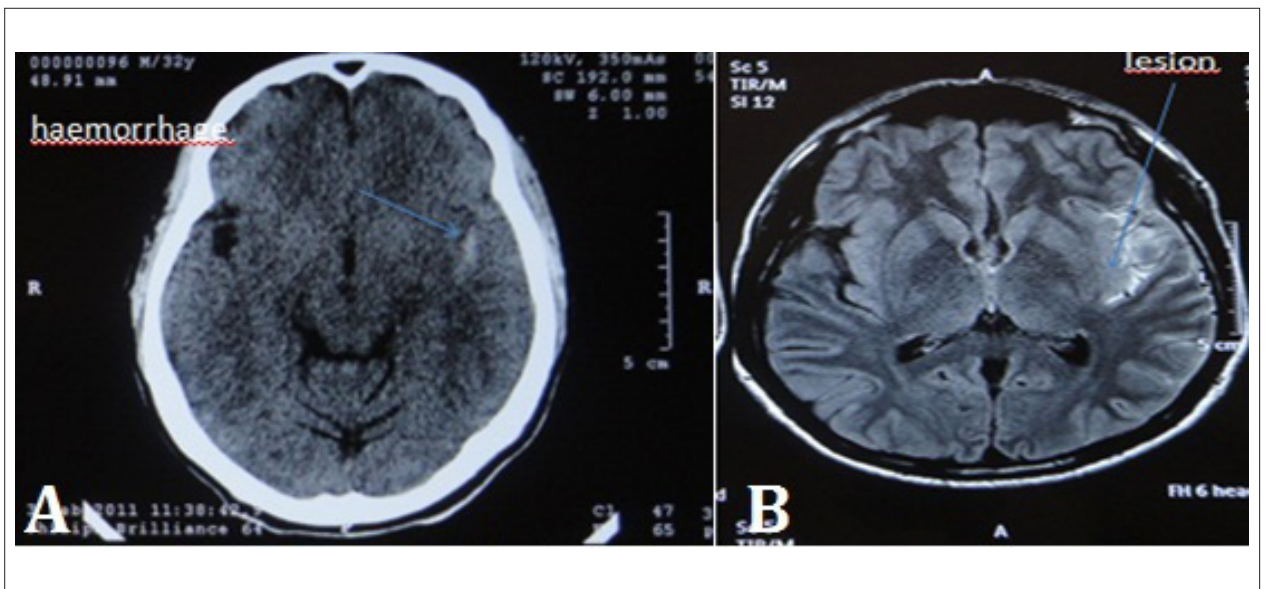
A - Computed tomography: of the brain parenchymal temporal hemorrhage . B - Cranial magnetic resonance imaging: hemorrhage with perilesional edema in the left temporal lobe.
